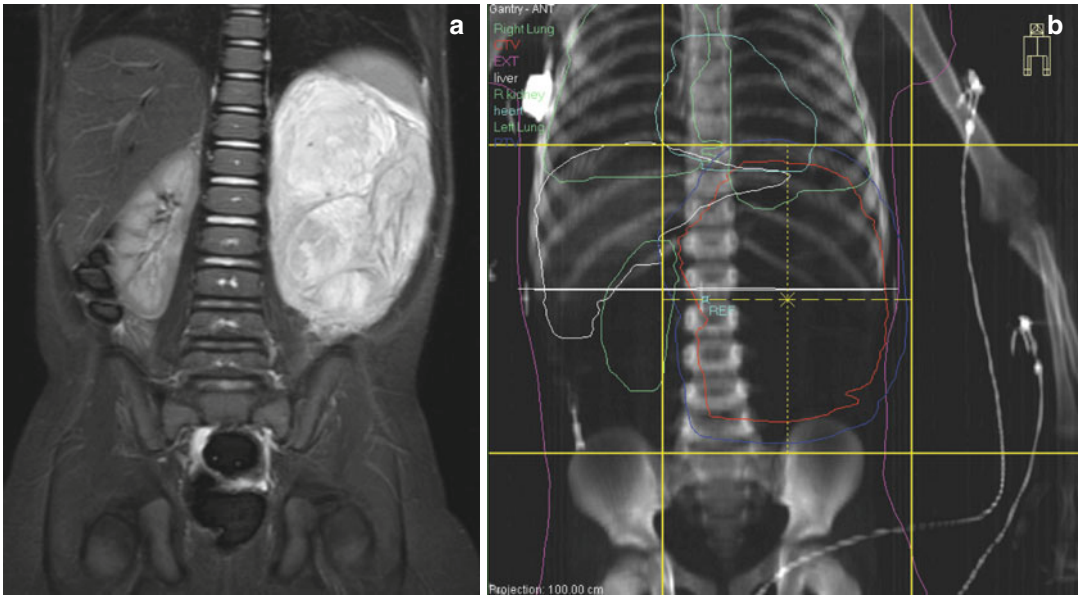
(a) MRI right Wilms tumor. (b) Radiotherapy planning CT scan. Red line is outlining the gross renal tumor volume with heart, liver, left kidney and spleen
